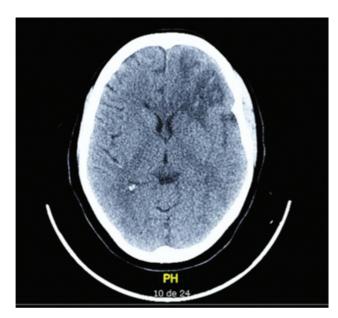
Computed tomography scan of the brain showing subcortical ischemic lesion in the left frontal region.
